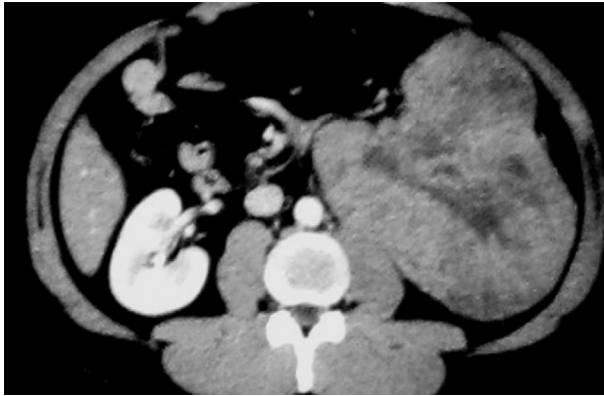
CT scan with contrast enhancement showing left renal mass
